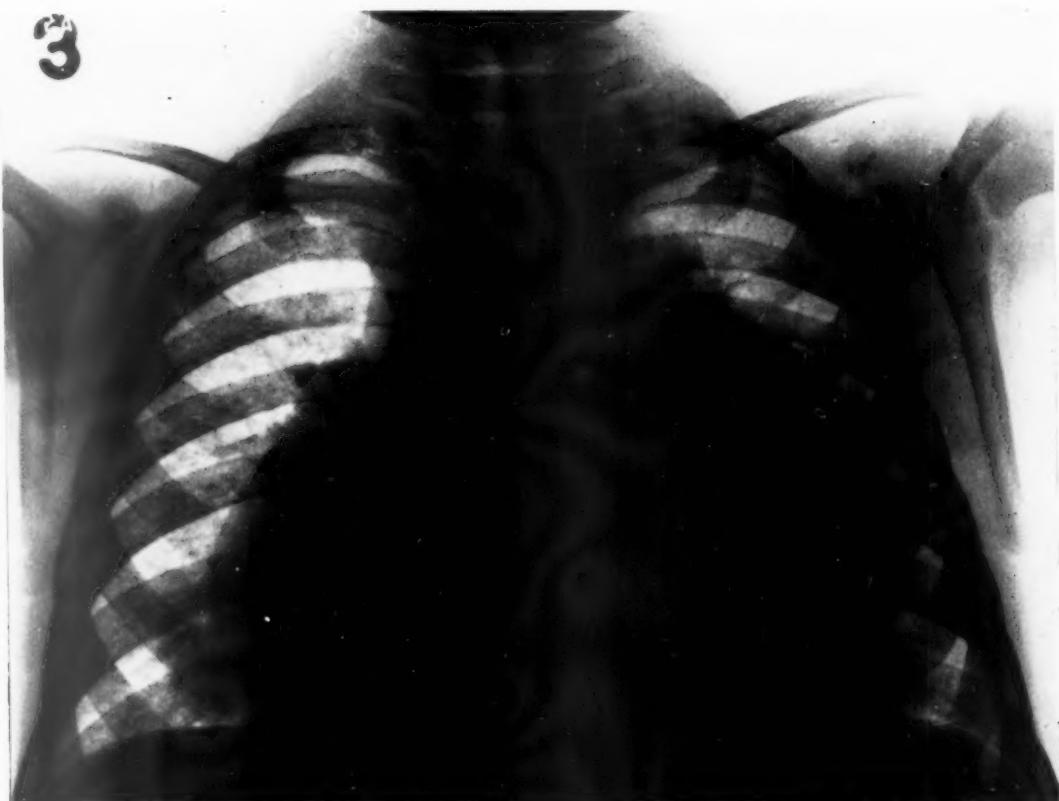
Postero-anterior radiograph of the thorax showing right-sided dilatation of the heart.
